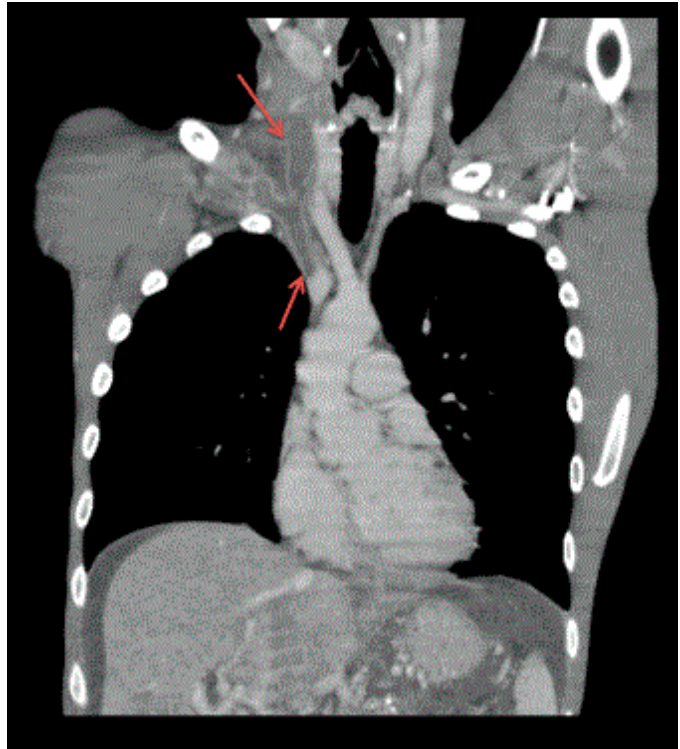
Computed tomographic pulmonary angiography with different views. We can see right axillary, subclavian and jugular veins thrombosis (A, B, C), started on origin of subclavian vein (d) and pulmonary embolism (E).
